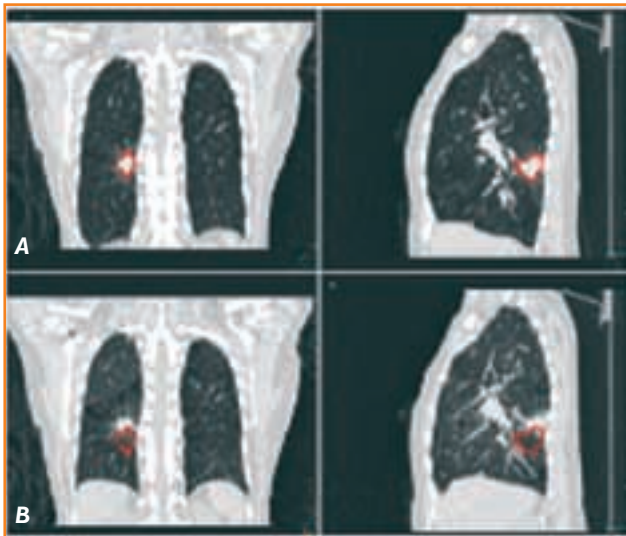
Respiratory-gated multiphasic CT images showing tumor movement during breathing. A: coronal (left) and sagittal (right) views at maximum inhalation. B: the same contours mapped to the maximum expiration phase reveal tumor movement. (Source: Klahr P, et al.¹¹)
